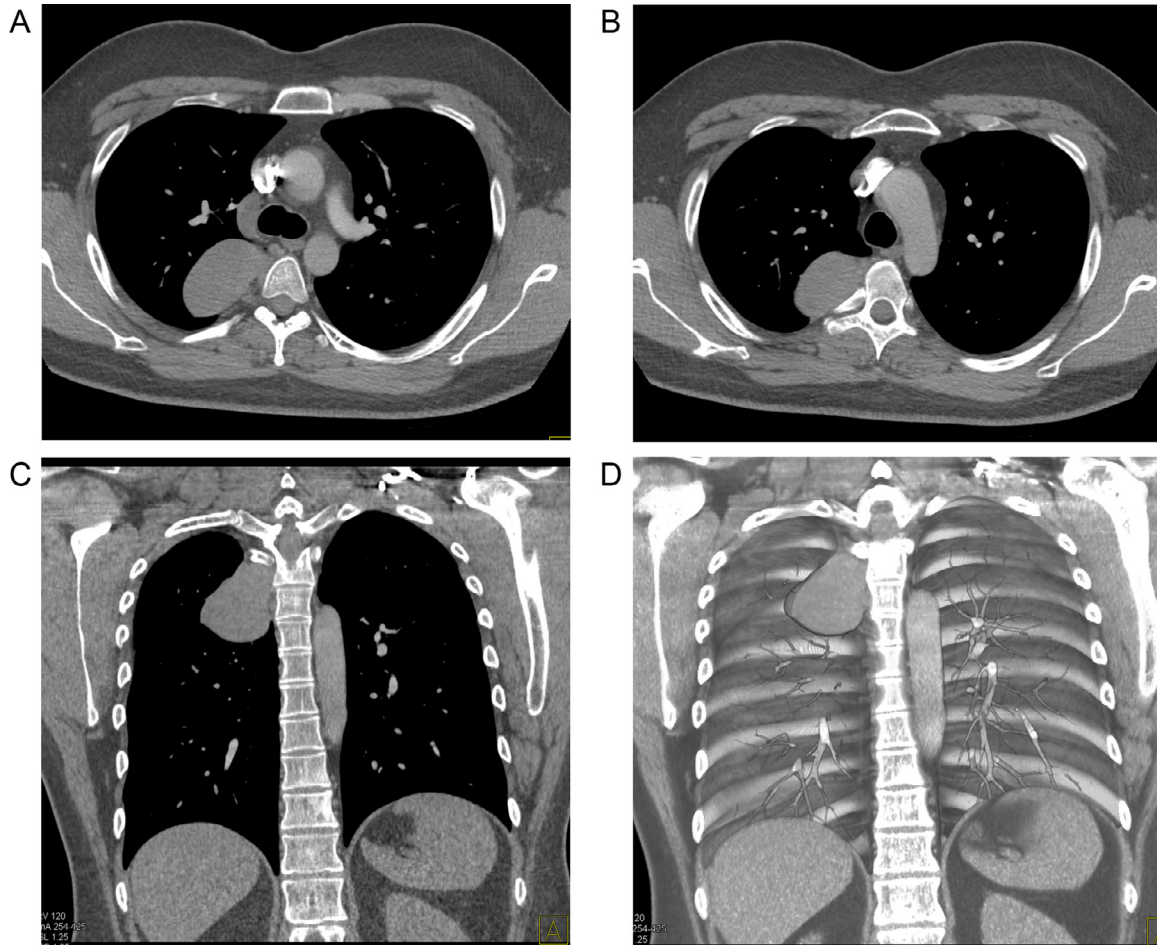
A 34-year-old male with an unclear smoking history presented due to palpitations. A chest computed tomography (CT) scan with IV contrast was performed for further evaluation. (A, B) Pleural-based mass is defined as soft tissue attenuation without erosion of the spine but abutting the pleural surface. The CT attenuation of the lesion was 44 HU. (C, D) Coronal view and volume rendered-view in coronal plane demonstrate the smooth borders of the tumor without bone invasion or enlargement of the neural foramina.
